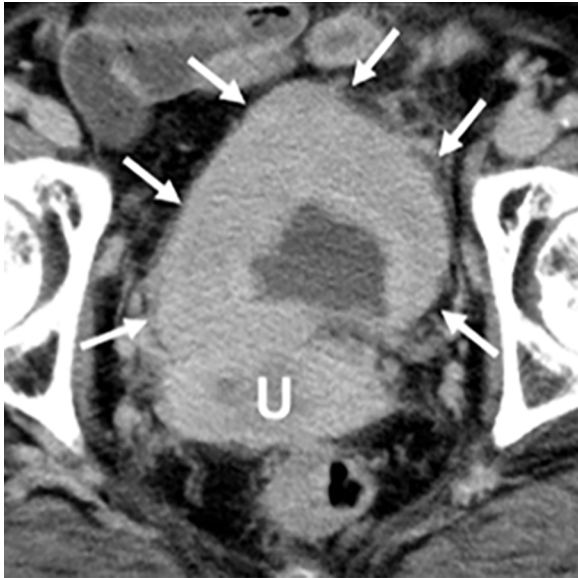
Contrast-enhanced computed tomography image of a patient with plasmacytoid urothelial carcinoma. The bladder reveals diffuse and marked wall thickening (arrows). The thickened bladder wall is in contact with the uterus (U).
